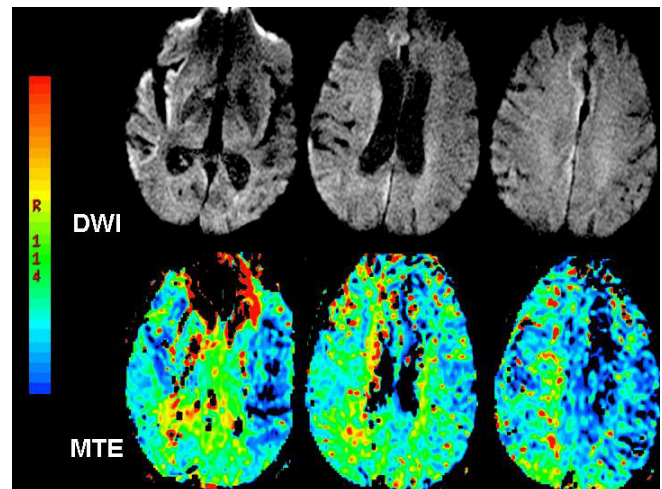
85 year old man with CJD. DWI (B=1000) shows high signal in the right sylvian cortex, caudate body, and cingulate gyrus. A slightly prolonged transit time is also seen in the right hemisphere.
